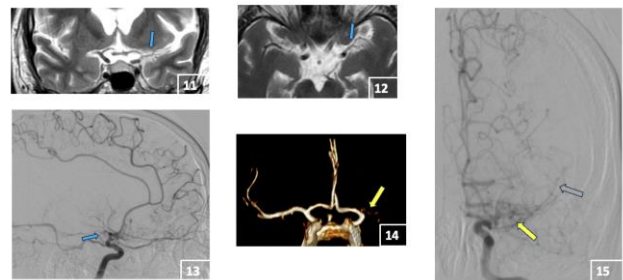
Case 3. Image 11: Coronal T2-weighted MRI showing the M1 trunk (blue arrow) and the bifurcation of the MCA. Image 12: Axial T2-weighted MRI showing the M1 trunk (blue arrow) alongside the MCA bifurcation. Image 13: Lateral cerebral angiography showing no MCA trunk, with a plexiform network of small arteries (blue arrow). Image 14: 3D reconstruction from angio-MRI showing absence of the left MCA, replaced by a small vessel network (yellow arrow). Image 15: Frontal cerebral angiography showing an intact carotid artery without discontinuity; the MCA is absent and replaced by a mildly dense plexiform vessel network (yellow arrow), with cortical distal MCA branches marked by a grey arrow.
